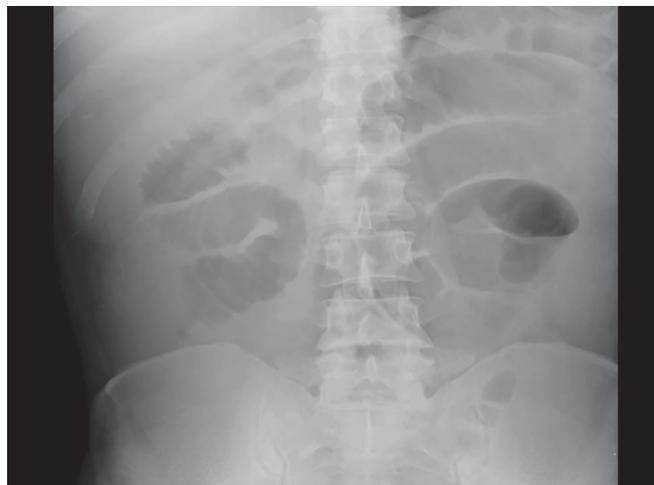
Abdominal X-ray that shows a sub-occlusive image due to colonic stenosis.
